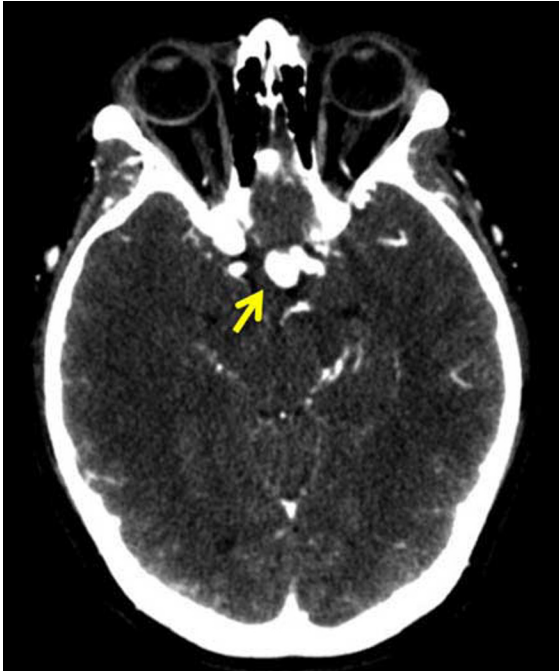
37-year-old female with an unruptured superior hypophyseal aneurysm. Contrast-enhanced CT showing axial images of the head. A hyperdense region is visualized at the level of the suprasellar cistern (yellow arrow) consistent with an intracerebral aneurysm.
